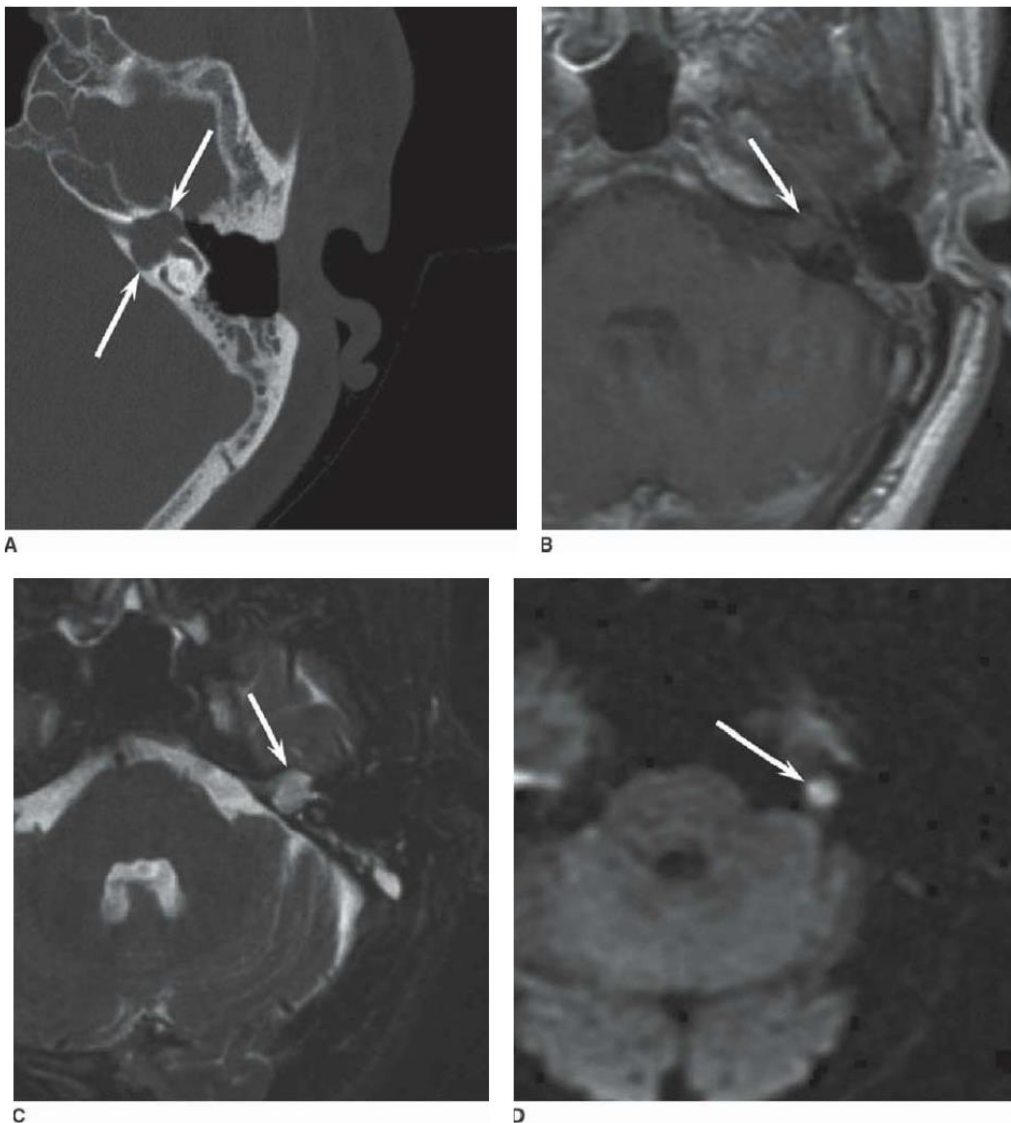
Radiographic appearance of recurrent acquired cholesteatoma. Axial CT of the temporal bone demonstrating a mastoidectomy defect with a smooth expansile mass (arrows) eroding the inner ear (A). This mass is isointense to brain and nonenhancing on axial T1-weighted contrast-enhanced MRI image (B), but hyperintense on T2-weighted images (C) and diffusion-weighted images (D). The restricted diffusion distinguishes recurrent cholesteatoma from scar.
